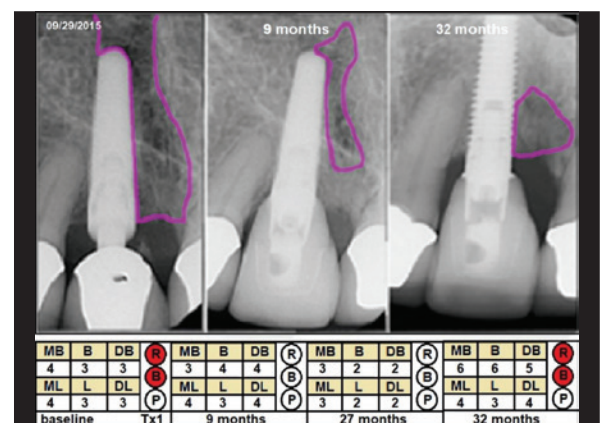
Example of a successful single treatment that was without clinical signs for over two years, and then the implant presented with signs of reinfection (Case 3), showing changes in radiographic defect (mm²), probing depth (PD; mm) and clinical signs from baseline to 32 months later. Violet = cross-sectional area; MB = mesiobuccal PD; B = buccal PD; DB = distobuccal PD; ML = mesiolingual PD; L = lingual PD; DL = distolingual PD; R = redness; B = bleeding; P = suppuration; Tx1 = first treatment.
